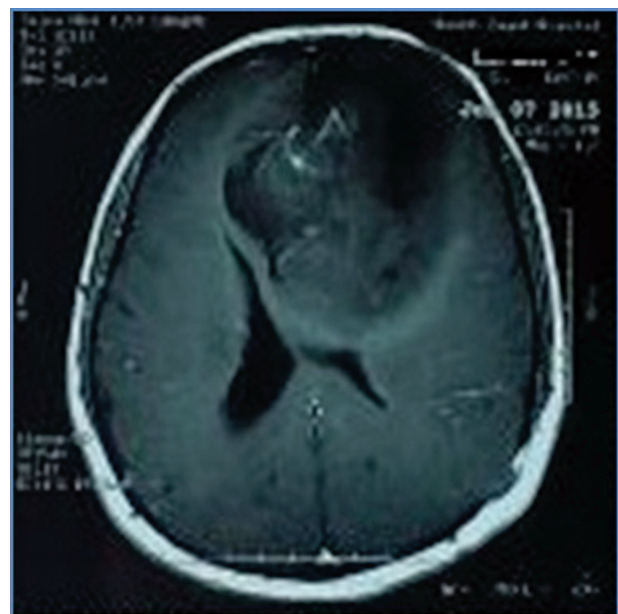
T1-weighted contrasted axial MRI scan showing a large heterogeneous left frontal glioma with contrast enhancement, significant mass effect, and invasion across midline. MRI, magnetic resonance imaging.
